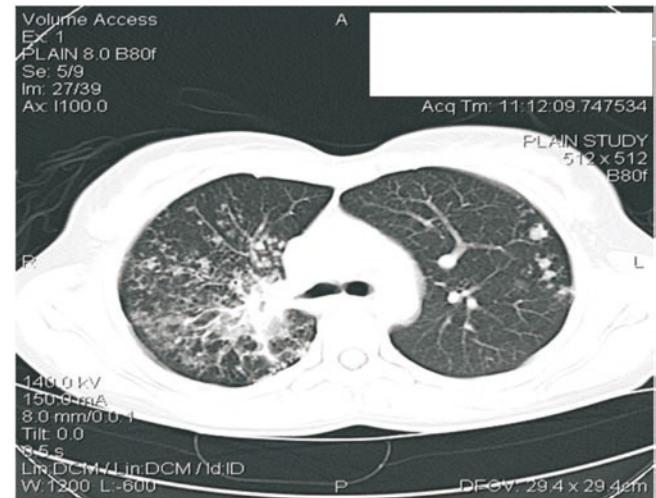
HRCT thorax at presentation (baseline).
